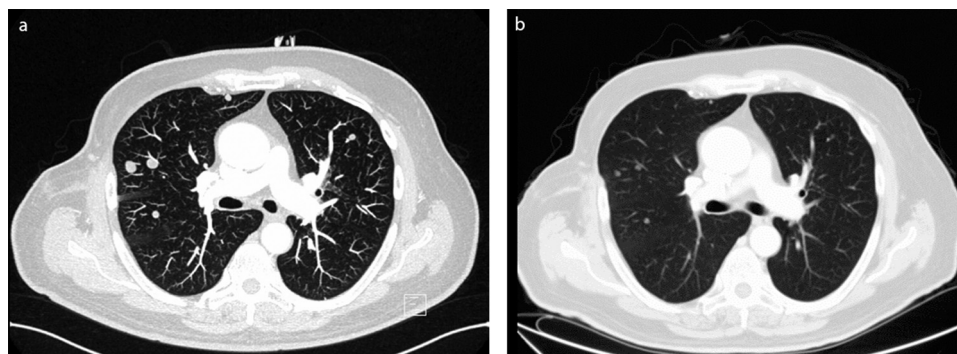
Bilateral, multiple, lung metastases from a malignant solitary fibrous tumour of the chest wall in a 67-year old man (contrast enhanced CT scan, arterial phase) before (a) and after 6 cycles of chemotherapy with doxorubicin and dacarbazine (b). A response in all lesions can be observed.
